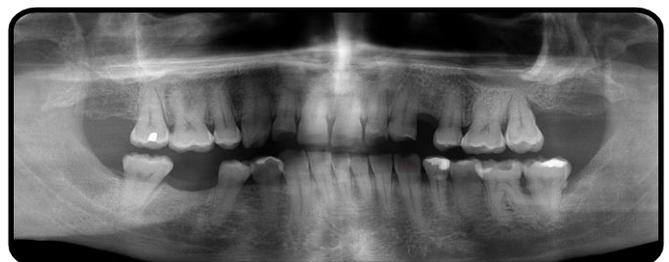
B - Standard panoramic radiograph for 63 M P shown that bone resorption after 6 months from tooth extraction.
